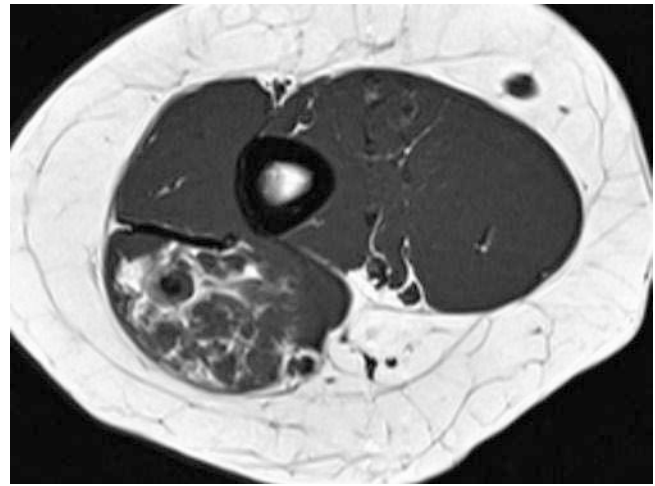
Intramuscular hemangioma in a 42 year-old woman. A T1-weighted image of the arm shows a mass within the long head of the triceps muscle composed of lobules and tubular structures interspersed with fat. An oval, black structure within a lobule represents a phlebolith
